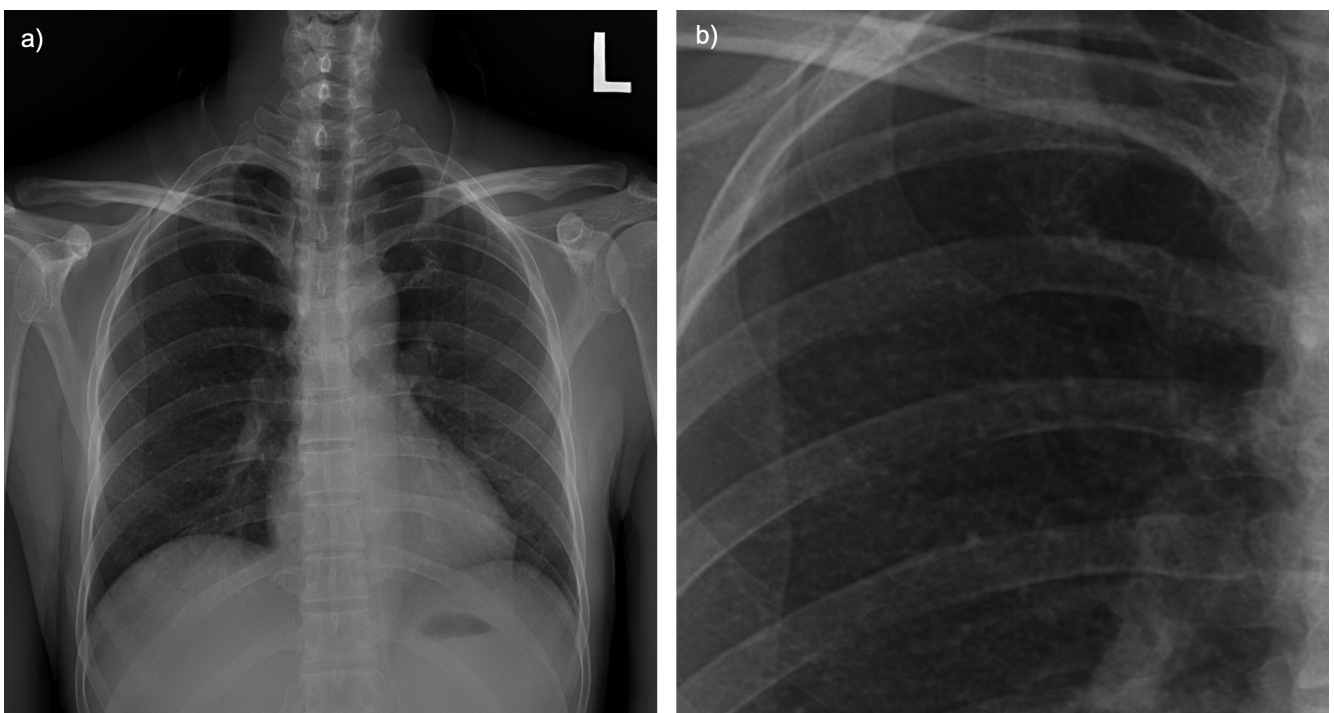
Patient # 3. a) Chest radiograph (posteroanterior) showing a profusion of p/p 1/2. b) Magnification of the chest radiograph.
